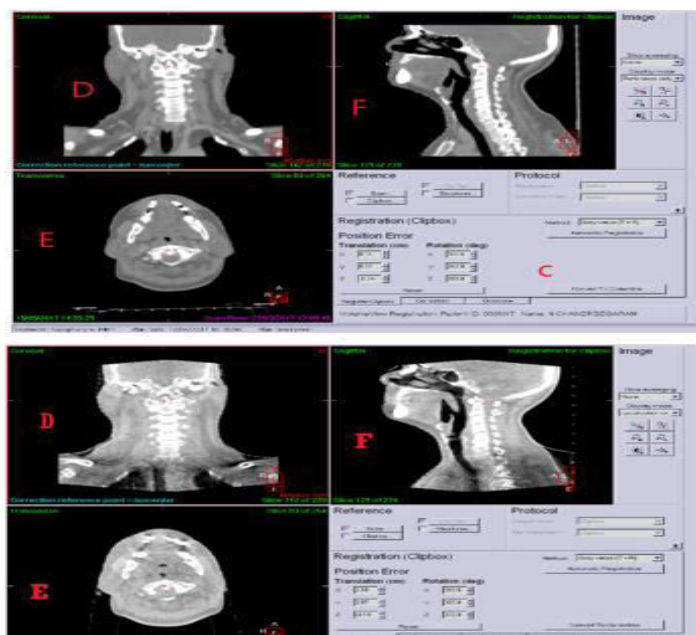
A-Planning CT image generated by treatment planning system. B-CBCT image obtained just prior to the delivery of treatment. C-Automatic registration. D-Coronal plane window. E-Axial plane window. F-Sagittal plane window.
